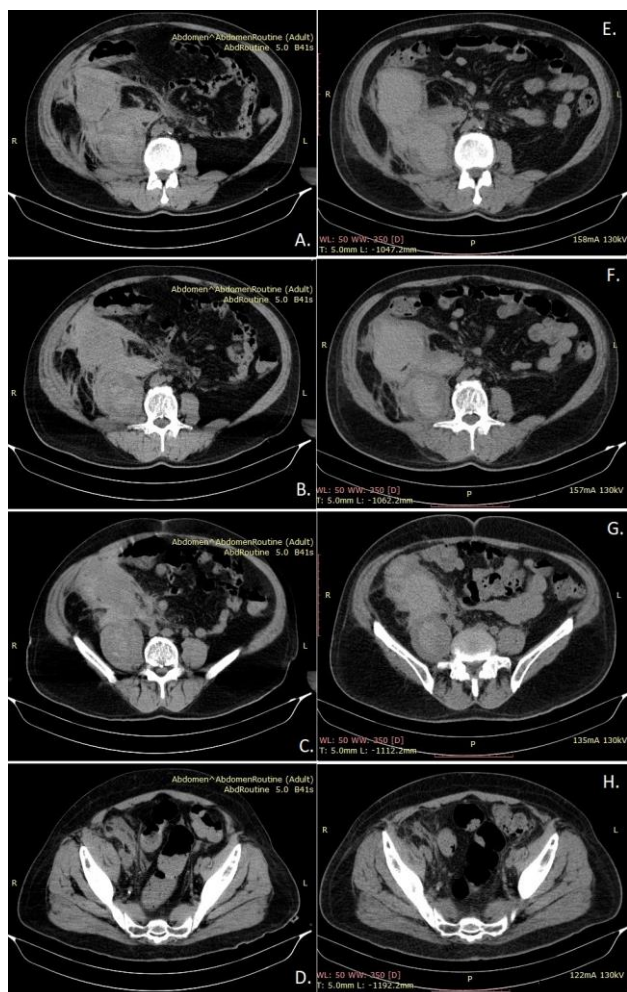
Retroperitoneal haematoma - first CT (A, B, C, D) and control CT on the 10th day (E, F, G, H).
